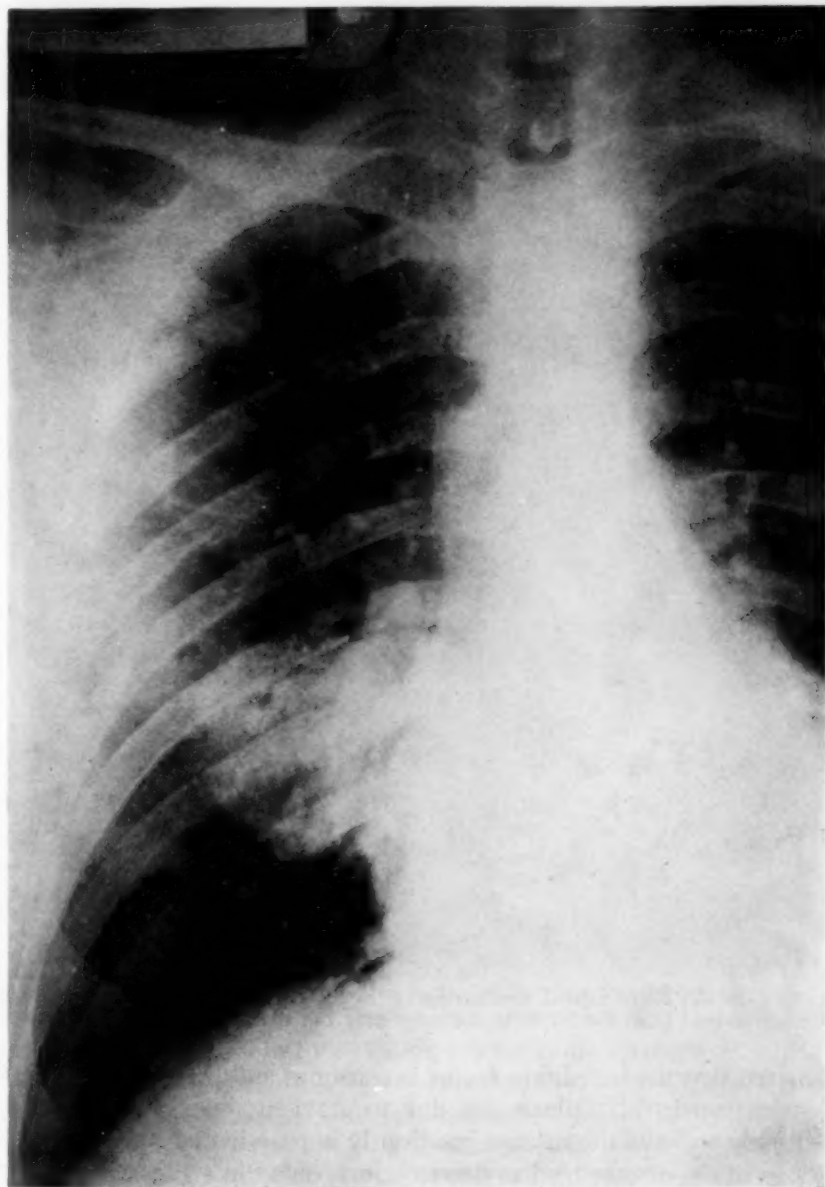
Case 2. PA roentgenogram of the chest revealing the enlarged hilar vessels and the well-defined vascular "tumor."
